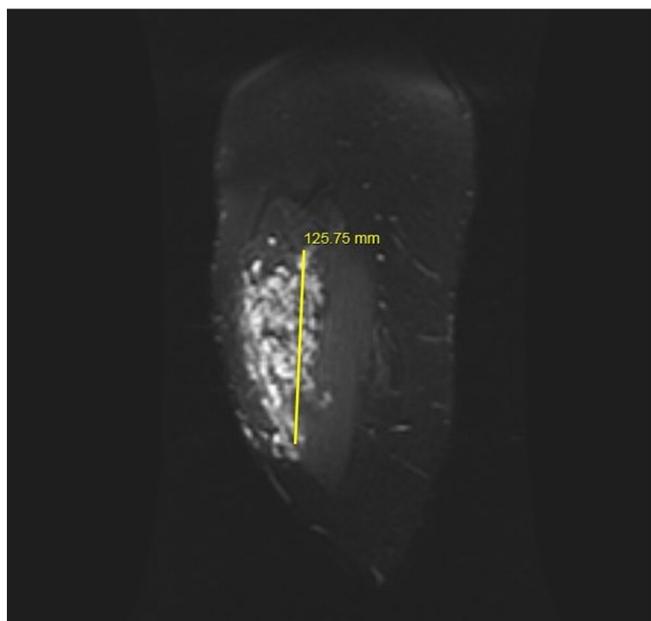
MRI of an intramuscular venous malformation in the right vastus lateralis.
